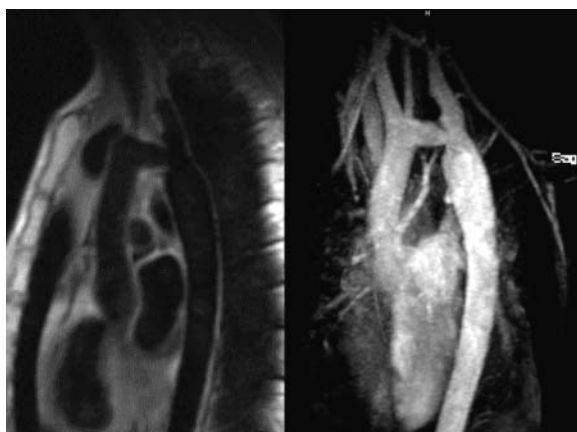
A patient after surgical correction of the aorta coarctation. Residual stenosis is visible in T1-weighted images and in MR angiography.
